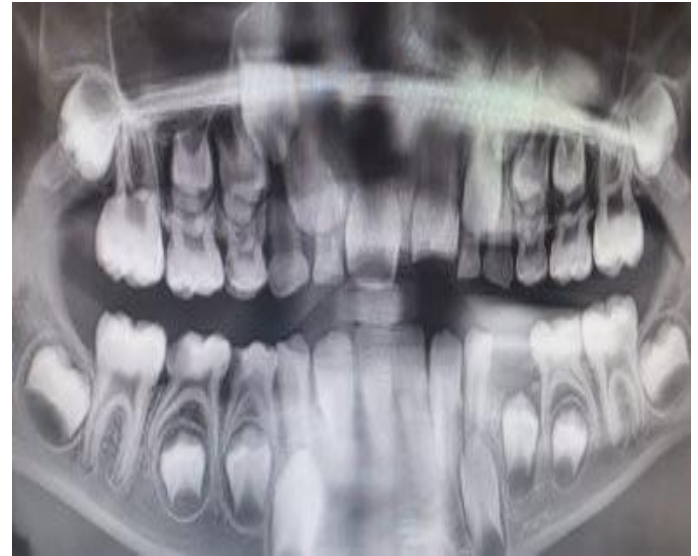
Radiographic image taken before treatment
